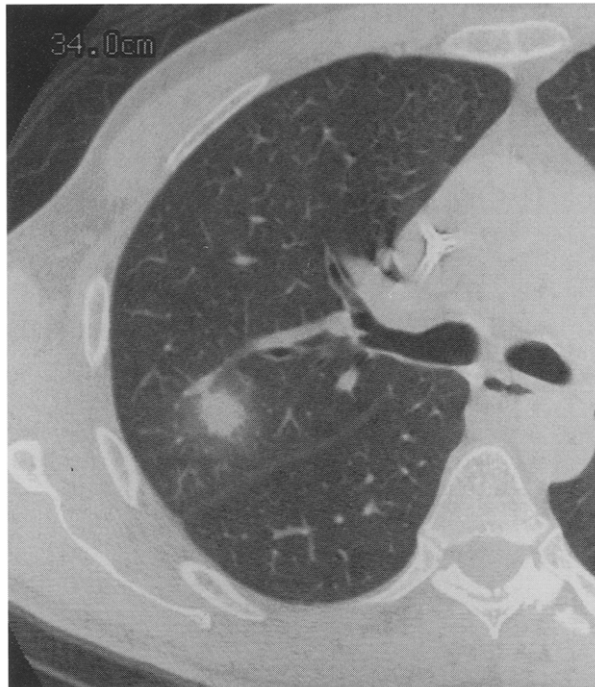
Thin-section contrast-enhanced chest CT image from patient No. 9 at a level 1 cm inferior to the carina demonstrating a dense 1.5 cm diameter nodular mass in the right upper lobe of the lung with a surrounding "halo."
